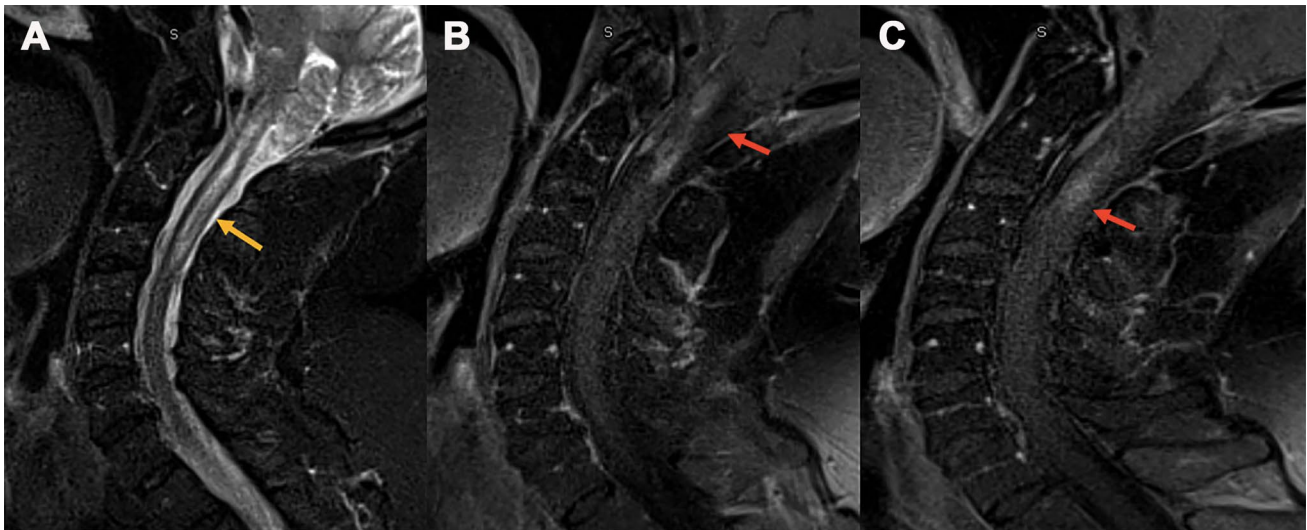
MRI sagittal STIR weighted image of cervical spine (a), sagittal cervical spine; sagittal T1 post contrast (b and c) reveals ill-defined long segment signal alteration with mild cord expansion (yellow arrow) (a) and abnormal enhancement on post-contrast study (b and c) (red arrow) extending from C1–C3 level
